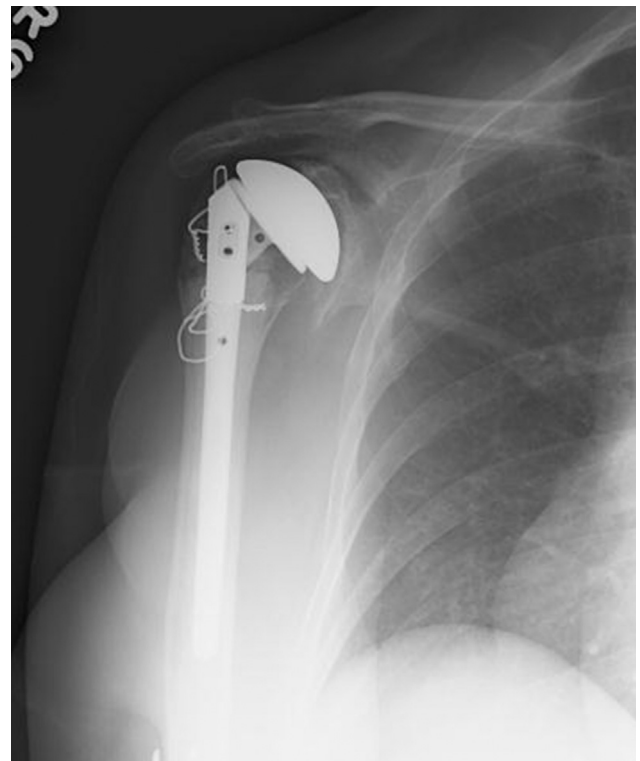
Anteroposterior radiograph of the right shoulder demonstrates an intra-operative tuberosity fracture that was secured with cerclage wires.
